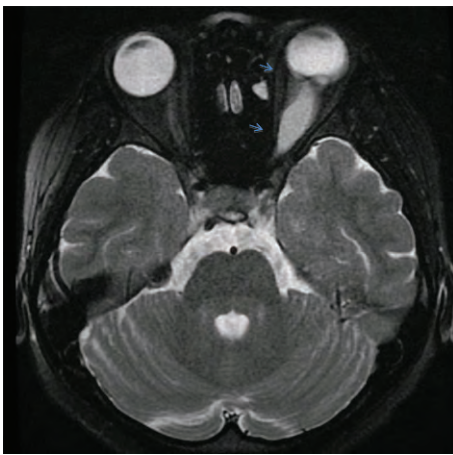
Optic nerve glioma; orbital axial imaging, fusiform thickening of the optic nerve; long T2 signal imaging is visible on T2WI in the SPIR-FLAIR.
